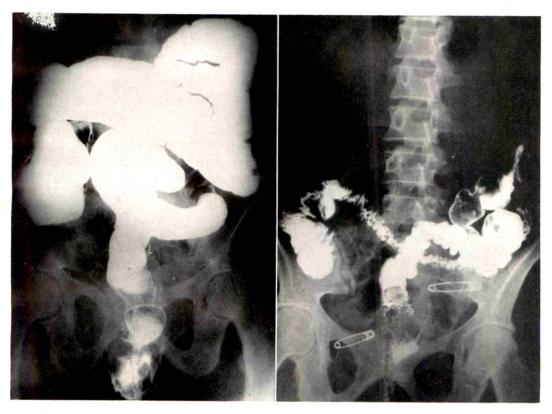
Ulcerative proctosigmoiditis of lymphogranuloma venereum; Frei test positive; the patient was a legress, thirty-four years old; she also had a rectovaginal fistula which confuses the roentgenologic picture to some extent; the proctoscopic diagnosis was lymphogranuloma venereum; *left*, roentgenogram of colon distended with opaque enema; *right*, after evacuation of opaque enema.
